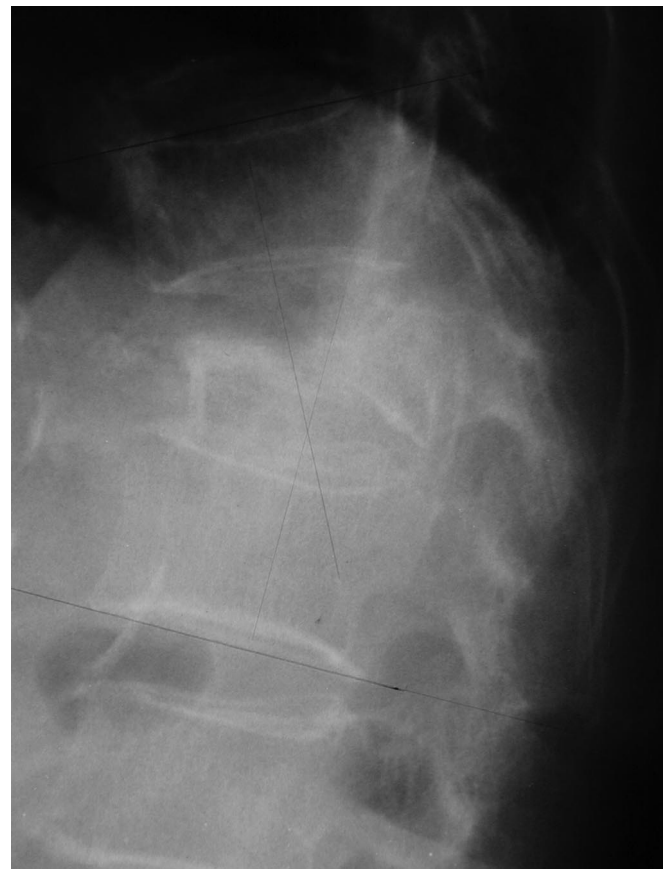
Thoracolumbar roentgenogram lateral view of an 85-year-old woman showed T12 osteoporotic compression fracture.
